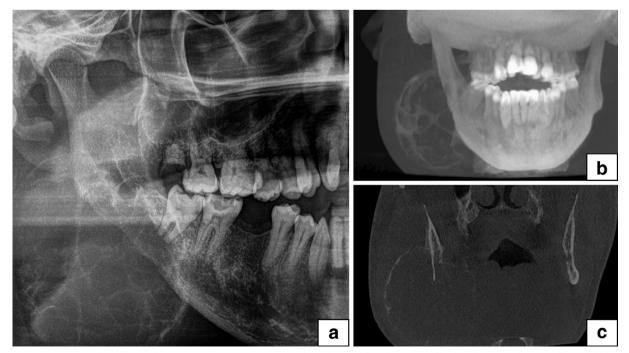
(A) Panoramic radiograph and (B) 3D CBCT reconstruction of a multilocular ABC affecting the posterior mandible withblow-out expansion of the cortical bone. (C) Coronal CBCT image shows an eccentric location in the bone with destruction of the lingual cortical plate.
